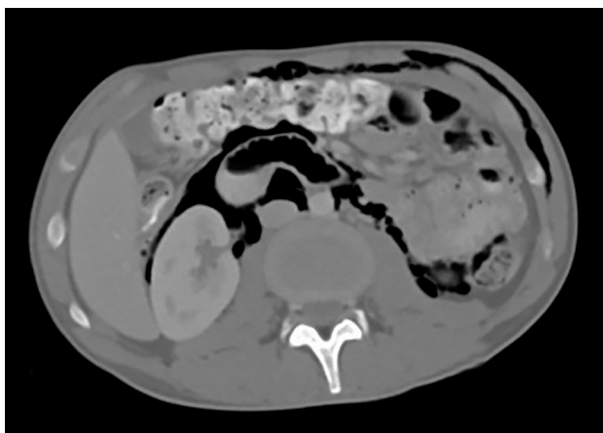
Axial CT cut, showing gas in peritoneum, retroperitoneum, and subcutaneous tissue.
